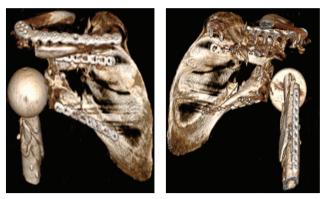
Postoperative CT scan of the same patient
